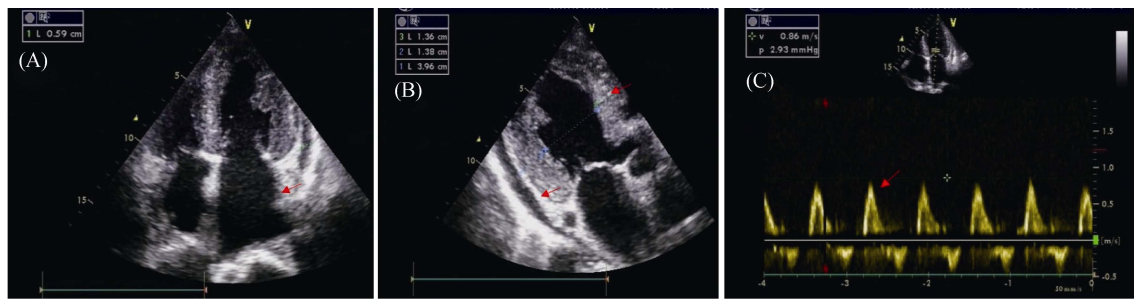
Echocardiography of the cardiac amyloidosis patient. (A): Echocardiography revealed dilated bi-atria (arrow); (B): symmetrically thickened left ventricular septum (14 mm), granular high echoic spots at the ventricular septum (arrow) and mild pericardial effusion (arrow); and (C): diastolic dysfunction with E/A (arrow), 74/31.
